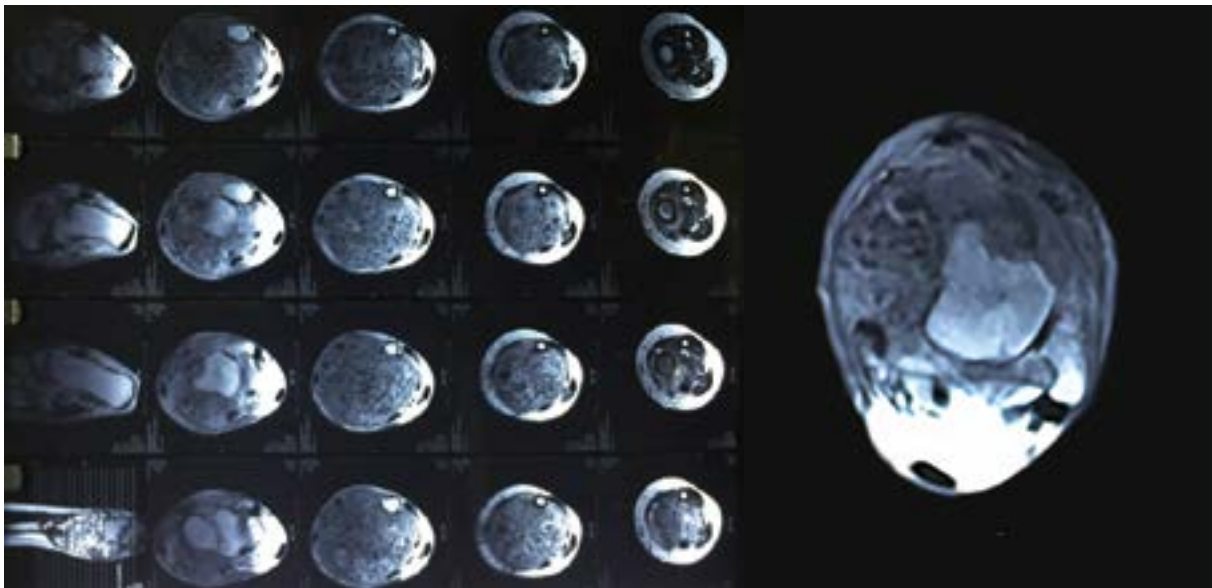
Magnetic resonance imaging of the ankle showed cortical destruction of the distal left tibia with minimum soft tissue involvement
